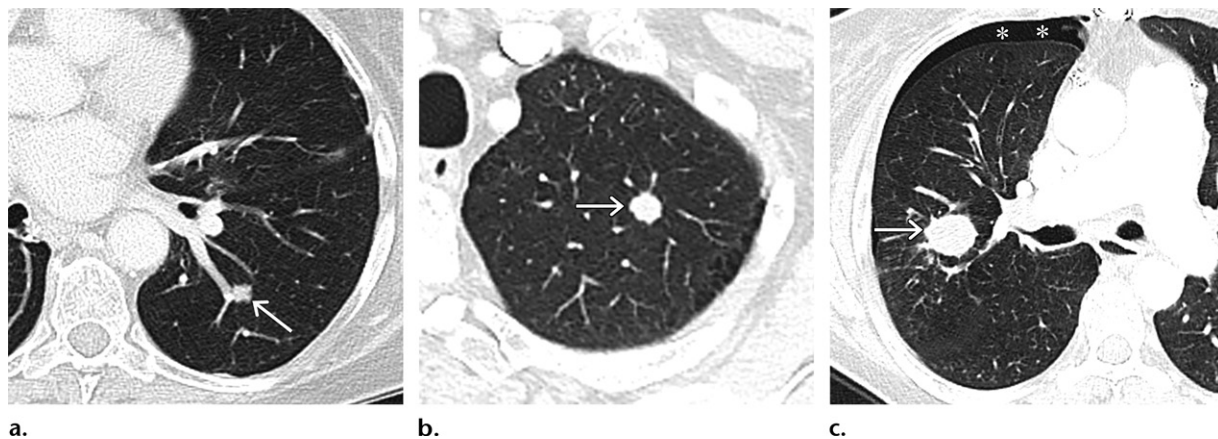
T1 tumor size. Axial contrast material–enhanced multidetector CT images of three different patients with NSCLC show the subdivisions of T1 lung cancers on the basis of 1-cm thresholds. (a) Image of a 69-year-old woman shows a T1a lesion (arrow); T1a lesions measure 1 cm or less. (b) Image of a 78-year-old man shows a T1b nodule (arrow); T1b nodules measure more than 1 cm and less than or equal to 2 cm. (c) Image of a 54-year-old woman shows a T1c tumor (arrow); T1c tumors measure more than 2 cm and less than or equal to 3 cm. Note the small pneumothorax (*) after CT-guided core needle biopsy.
